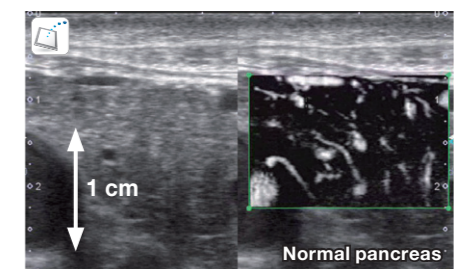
While conventional color Doppler poorly visualizes vasculature in a normal pancreas, SMI shows even fine vascular structure.
